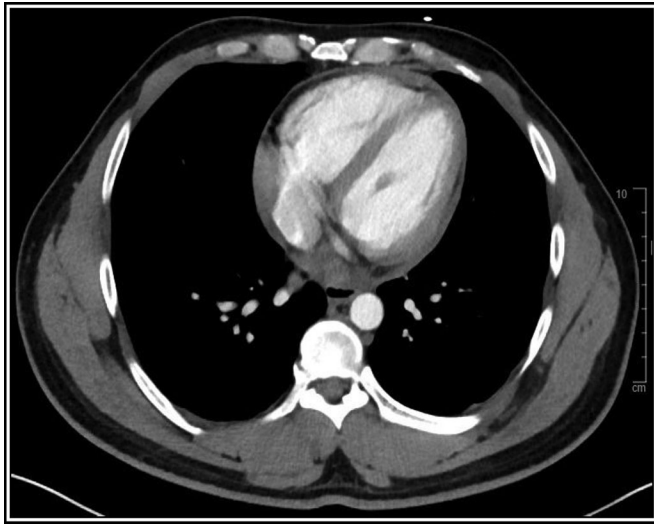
Axial computed tomography showing a moderate amount of intermediate to high intensity fluid present within the pericardial sac.
